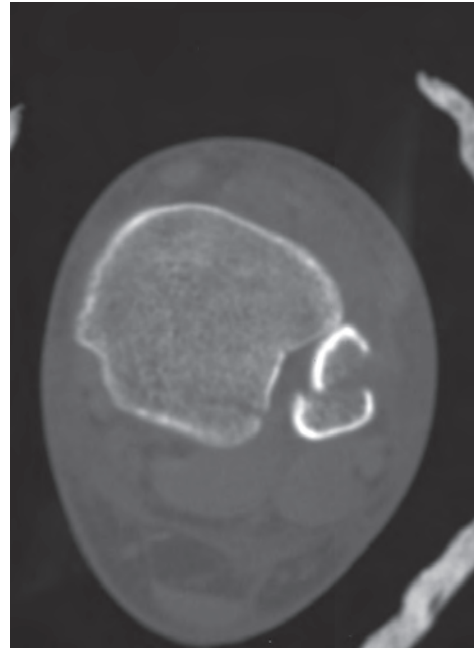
Computed tomography image.
